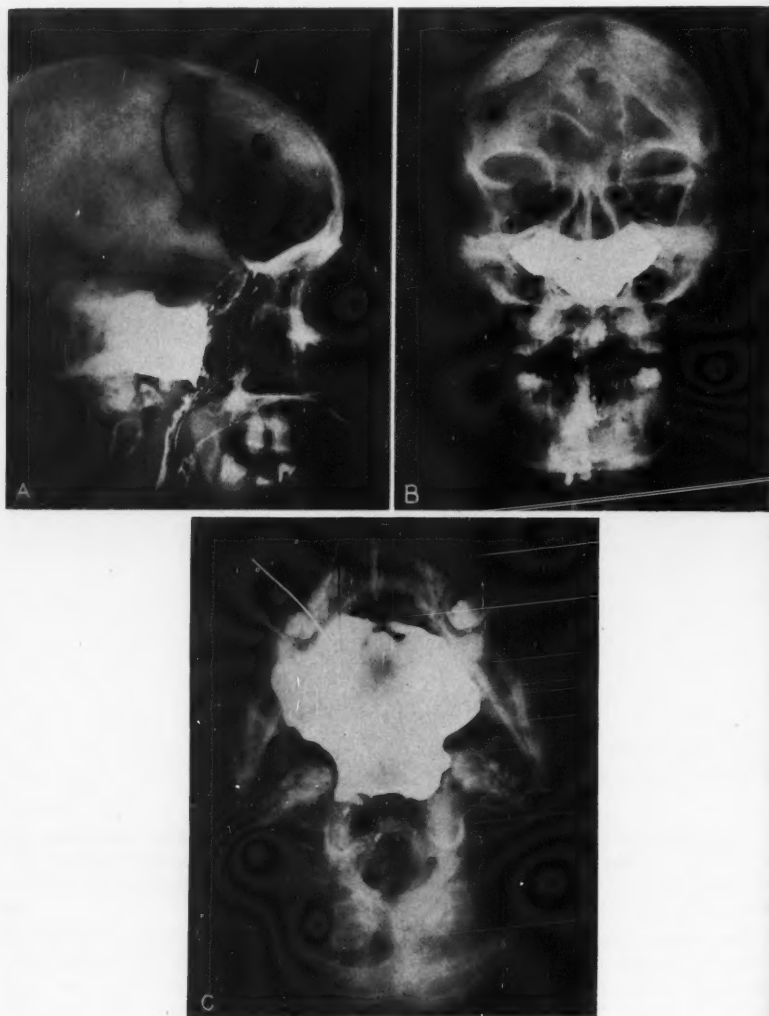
Roentgenogram of cavity after instillation of iodized oil immediately after operation.
